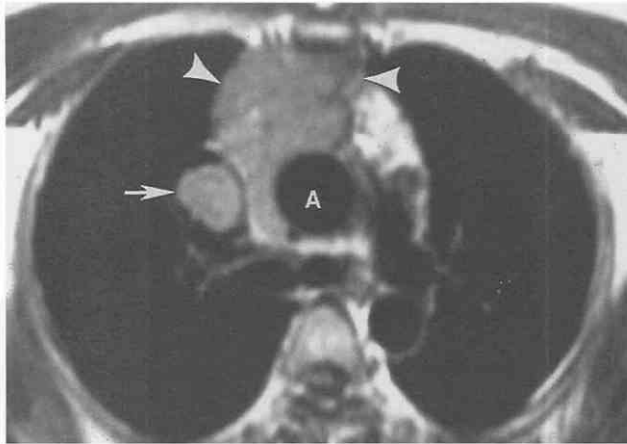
Invasive thymoma in a patient with symptoms of superior vena cava (SVC) obstruction. Axial T1-weighted MR images show infiltrative soft tissue mass (arrowheads) of intermediate signal intensity encasing the aorta and extending into the SVC (arrow). A, aorta. (From Erasmus JJ, McAdams HP, Donnelly LF, Spritzer CB: MR imaging of mediastinal masses. *Magn Reson Imaging Clin North Am* 8:59-89, 2000.)
